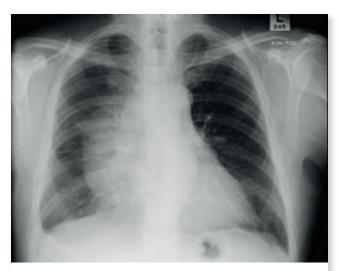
Chest x-ray showing a widened mediastinum that is hilar plus mediastinal lymphadenopathy secondary to Hodgkin lymphoma.
